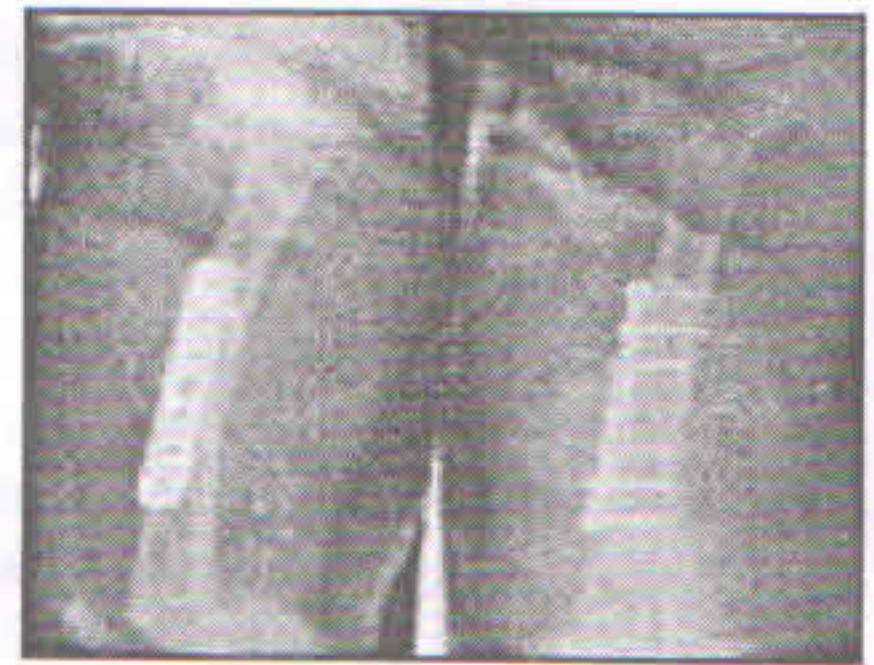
Followup x-ray of 1 month
